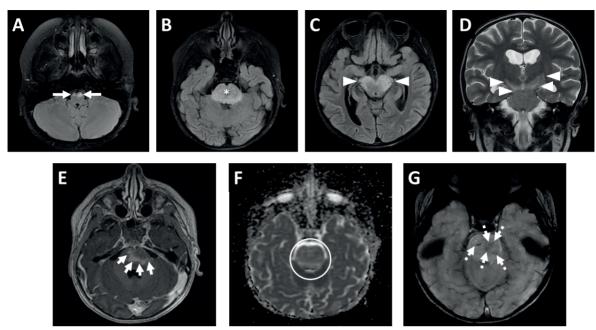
Brain MRI at the time of diagnosis of a 5-year-old girl with recurrent high-risk neuroblastoma who was unresponsive to verbal stimuli had paraparesis and left unilateral fixed dilated pupil after the third dose of dinutuximab. Axial FLAIR (*A*-*C*) and coronal T2-weighted (*D*) images demonstrate hyperintense signal on medullary pyramids (*long arrows*), pons (*asterisk*), and cerebral peduncles extending to the left internal capsule posterior limb (*arrowheads*). The lesion also demonstrated incomplete ring enhancement (*short arrows*) on the T1-weighted postcontrast thin-section image (*E*) and increased diffusion (*circle*) on the ADC map (*F*). In addition, linear and dot-like susceptibility foci (*dashed arrow*, *G*) in the pons on SWI images should be noted.
